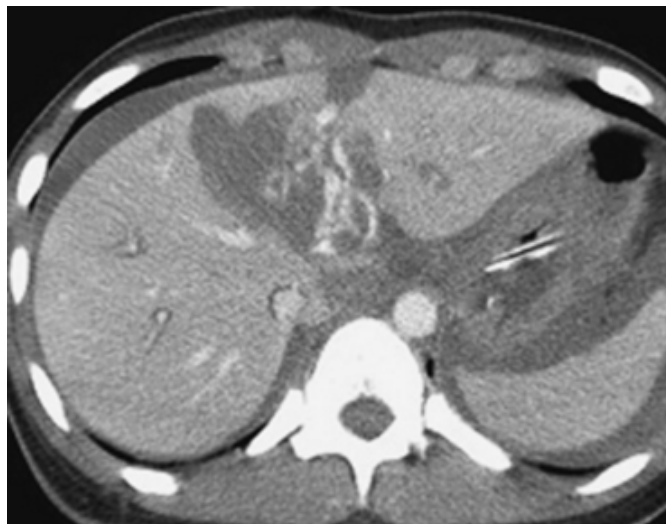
CT scan showing grade 5 multiple liver lacerations
